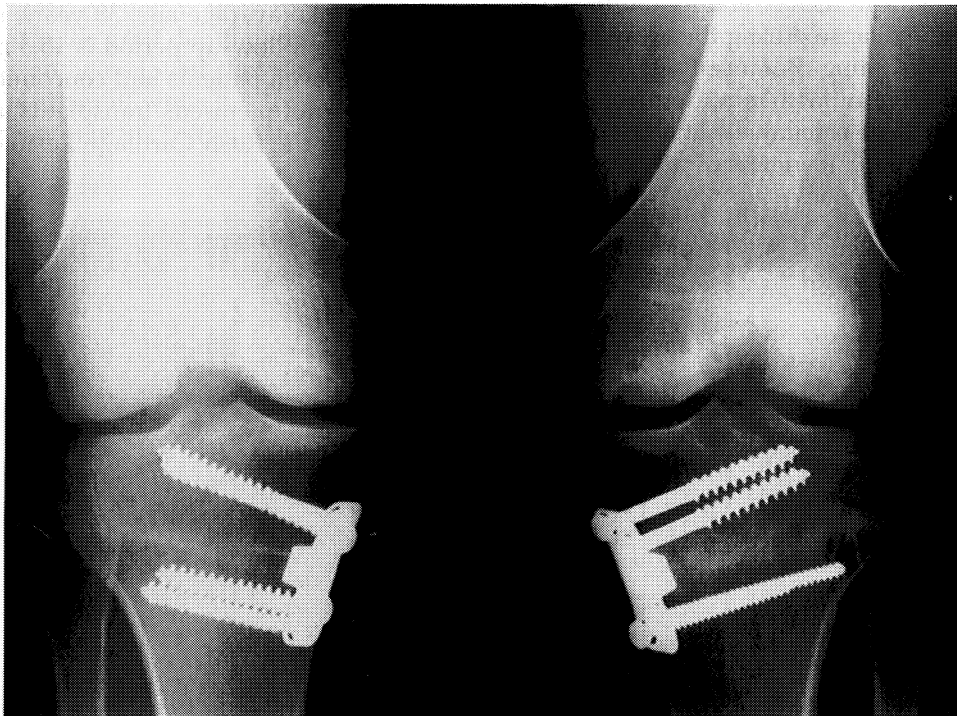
One-year radiograph following revision allograft surgery and osteotomy of the left knee and 2-year radiograph of the right knee following osteotomy and osteochondral grafting of the same patient in Figure 12, demonstrating bilateral healed opening wedge osteotomies and well-incorporated osteochondral allografts of the medial femoral condyles.
